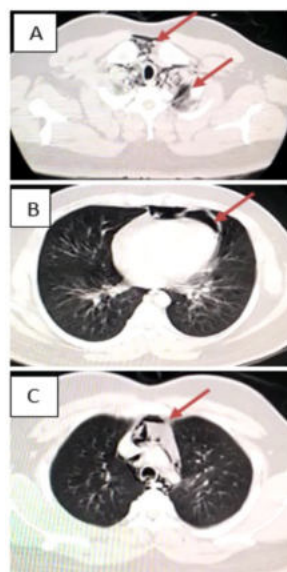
(A-C)., CT thorax images taken during admission Showing.
